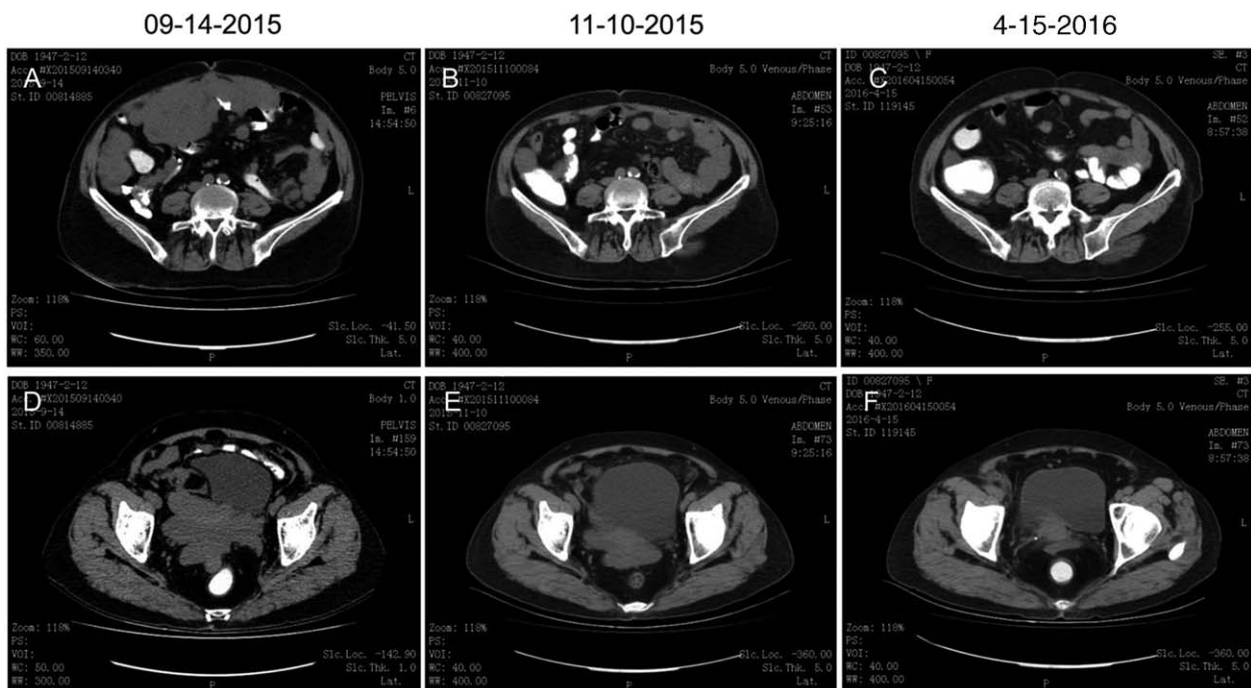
A computed tomography scan showed coexisting abdominal and pelvic masses (A and D) at the time of initial diagnosis. The size of mass lesions in abdominal and pelvic locations decreased significantly following treatment with apatinib of 500mg daily (B, C, E, and F).
